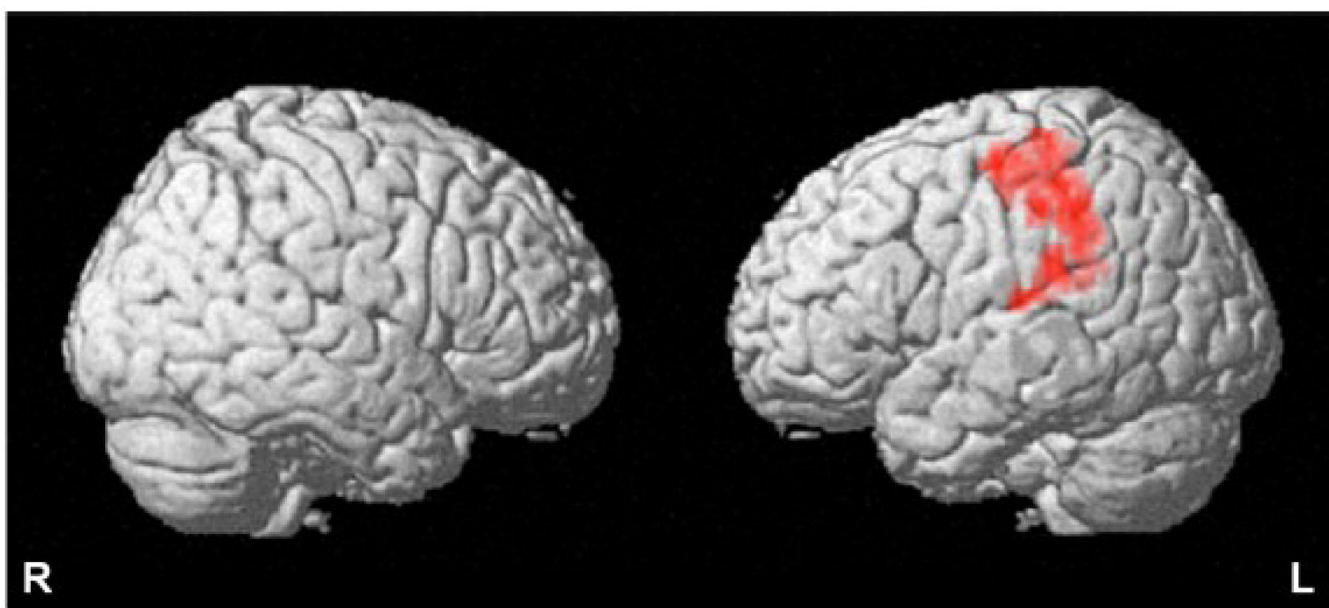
Spatial distribution of functional brain MRI activation showing positive interaction of WMH burden by accuracy during sDSST task
